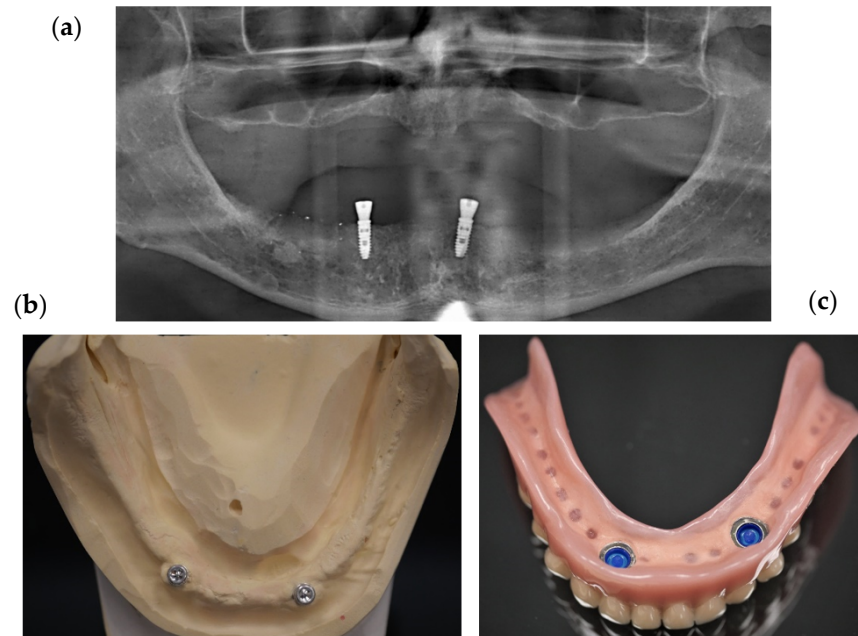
(a) Panoramic X-ray of an edentulous patient with two interforaminal implants showing a distinct inter-implant angulation, (b) Mandibular cast of the patient shown in Figure 1a with two male Locator attachments in place, (c) Removable prosthesis with female parts of the Locator attachment system.
